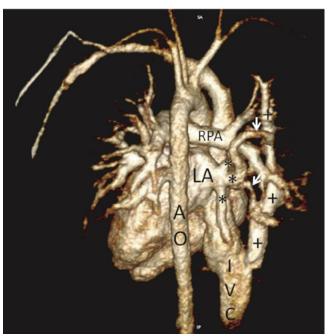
Three-dimensional reconstruction of cardiac MRI (posterior-anterior view). The anomalous drainage of the lower pulmonary right vein into the IVC with slight stenosis of the vessel at the diaphragm is evident. In addition, all three right pulmonary veins are connected to the left atrium. AO = descending aorta; IVC = inferior vena cava; LA = left atrium; RPA = right pulmonary artery; * pulmonary veins; + scimitar vein; arrows, additional vein connecting the lower and middle right pulmonary vein.
